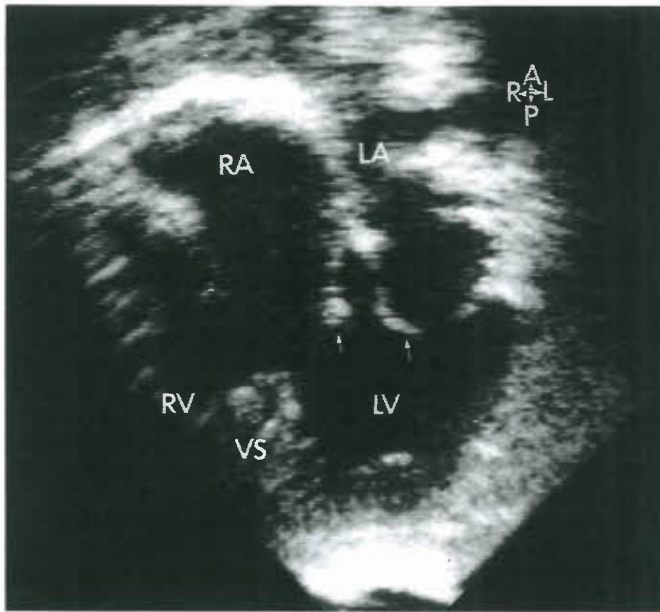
Apical four-chamber view demonstrating double-inlet LV with straddling right AV valve. More than 50% of the right AV valve annulus is committed to the left-sided morphologic LV. Arrows point to abutting leaflet of the right and left AV valves. LA, left atrium; RA, right atrium; RV, right ventricle; VS, ventricular septum.
